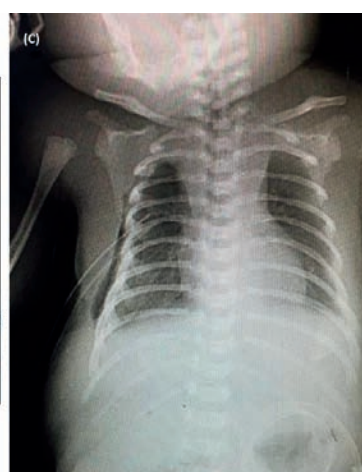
Ultrasound guided fetal thoracocentesis. (A) Massive pleural effusion with collapsed right lung (white arrow) causing mediastinal shift (white circle); chiba needle (white star) is introduced. (B) Following drainage. (C) Resolution with thoracostomy.
